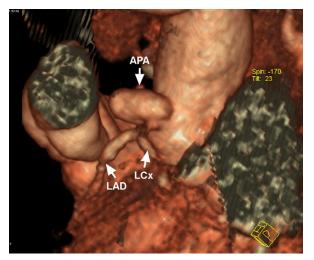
Computed tomogram with 3-dimensional reconstruction shows the aortic pseudoaneurysm (APA) from the posterior aspect of the heart.
